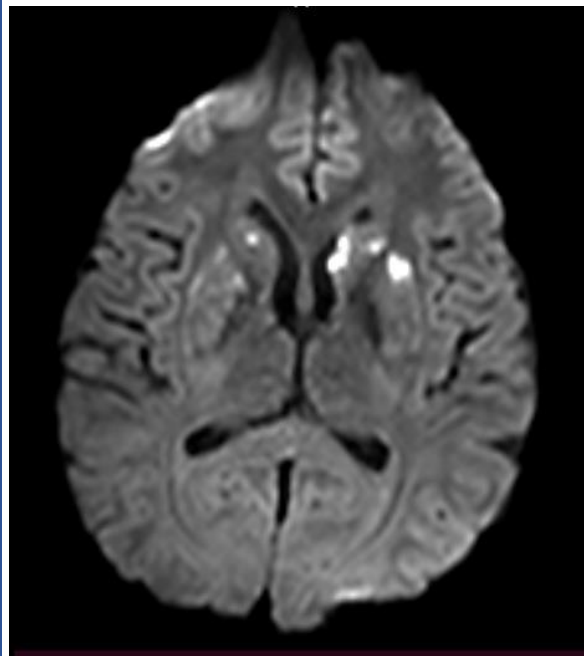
Diffusion weighted image of MRI brain showing infarcts in bilateral caudate nuclei and left lentiform nucleus
